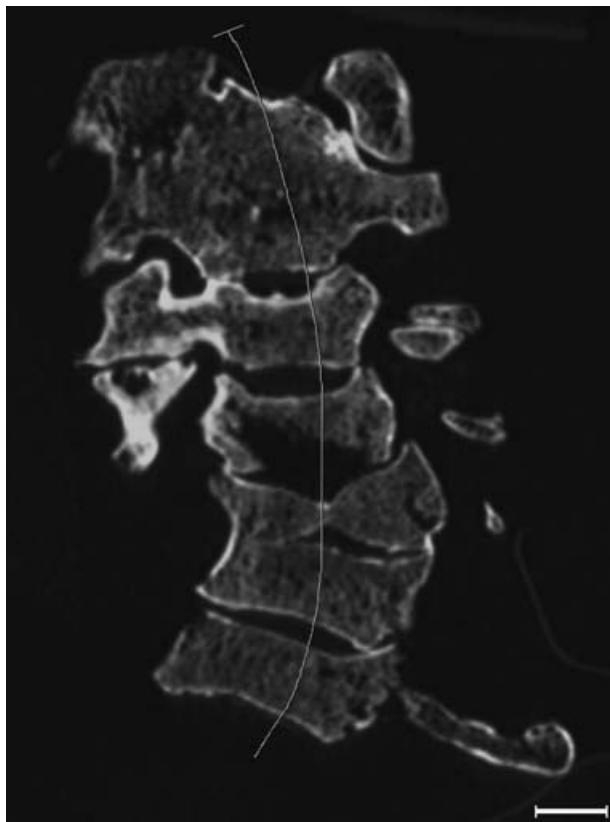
CT scan showing the C1–C2 and C5–C6 vertebral blocks, C5 butterfly vertebra and cervical dextroscoliosis (scale of 1 cm).
